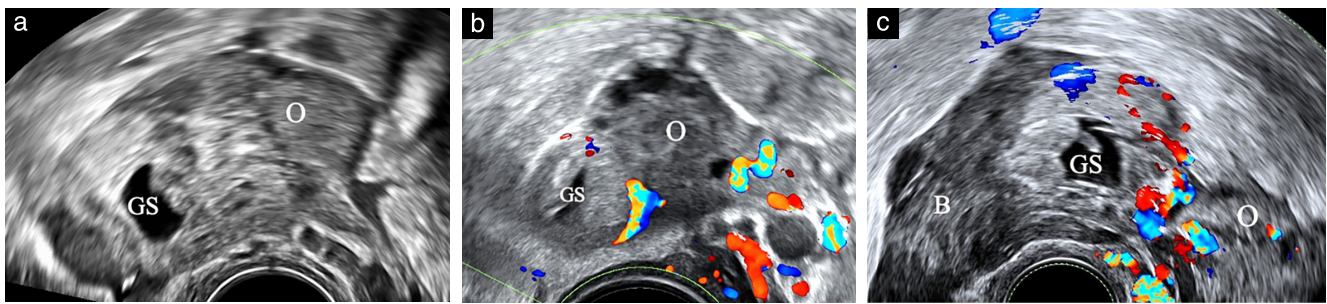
Grayscale (a) and color Doppler (b,c) transvaginal ultrasound images of ovarian ectopic pregnancies, showing: (a) gestational sac (GS) confined within ovary (O); (b) GS with prominent blood supply protruding partially outside O; and (c) GS protruding through O adjacent to blood clots (B).
